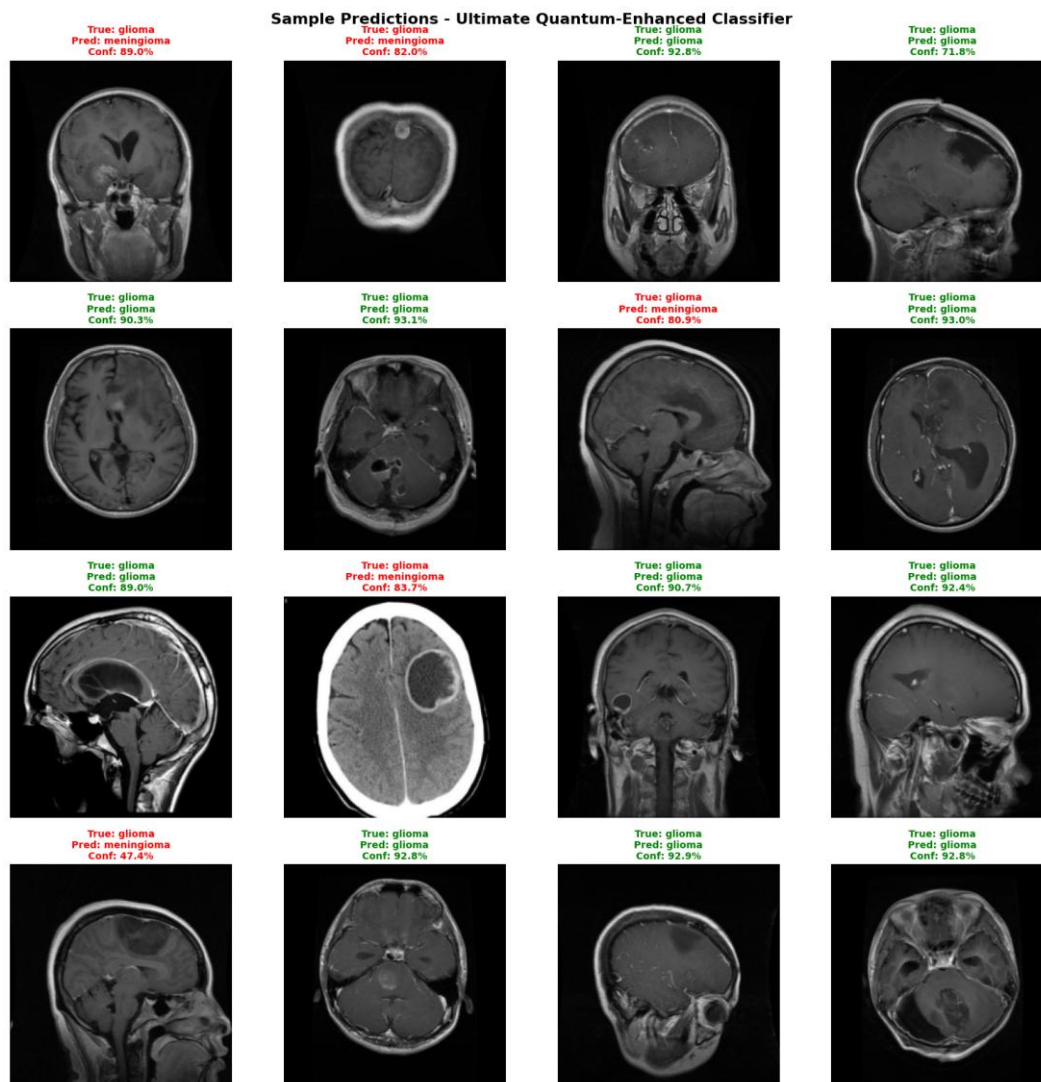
Sample MRI Predictions from the QCHNA on Glioma Test Cases. Green annotations indicate correct predictions; Red annotations indicate misclassifications. Confidence scores are displayed for each prediction.
